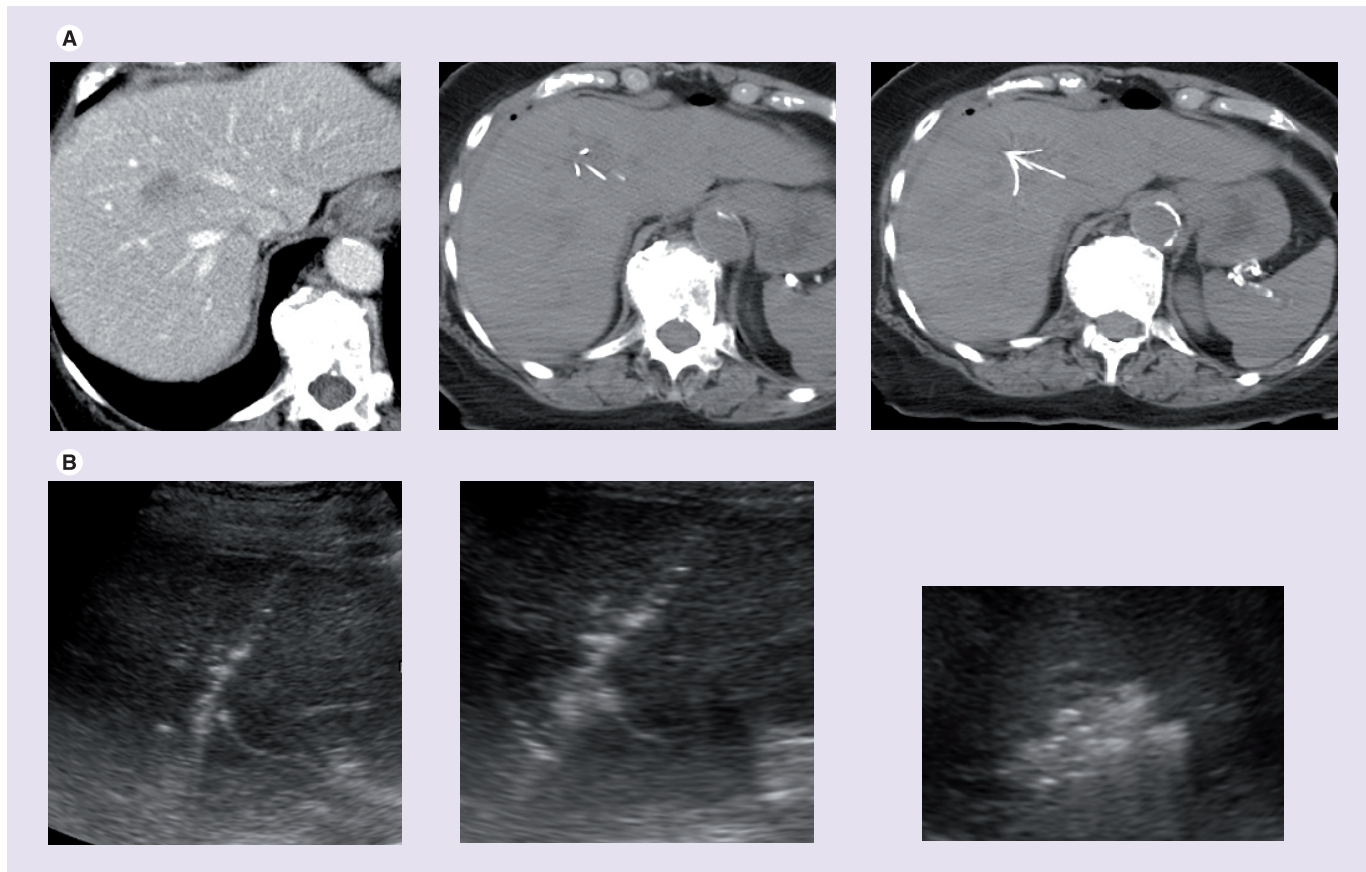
Confirming radiofrequency ablation probe location. (A) Contrast-enhanced CT demonstrating an ideal lesion for ablation. The proximity of the lesion to the hepatic veins is more than 1 cm, allowing ablation with a good margin. Two intraprocedural CT images demonstrating deployment of a multitined radiofrequency electrode. Care is taken to demonstrate adequate coverage of the target lesion. (B) Ultrasound confirms targeting in real time and allows the monitoring of the created hyperechoic ablation zone that slowly covers the hypoechoic lesion.
